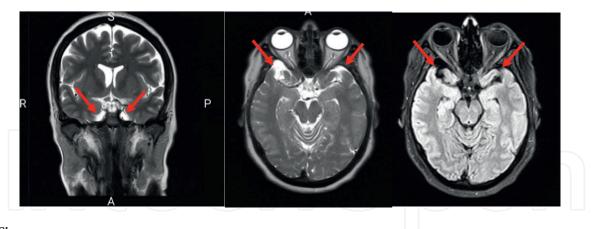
Bilateral encephaloceles showing by red arrows in brain MRI (a) T2 weighted coronal cut; (b) T2 weighted axial cut at the same level; (c) T1 weighted axial cut at the same level (Bita Shalbafan courtesy).
